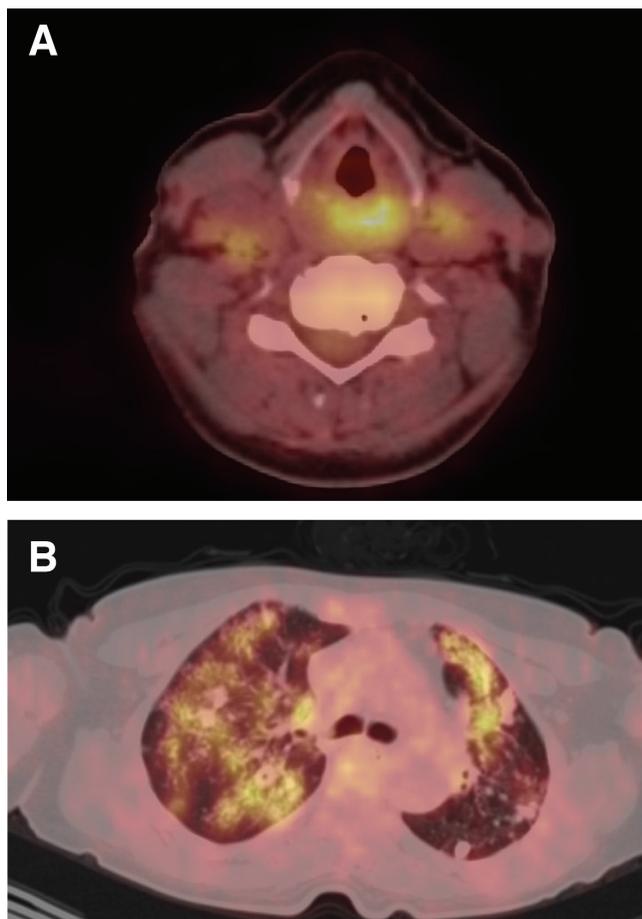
PET/CT fusion images showed hypermetabolic foci in the left aryepiglottic fold and interarytenoid area maximum standard uptake values (SUV_{max}): 8.9 (A). On transaxial thorax fusion images, there were multiple hypometabolic nodules (SUV_{max} : 1.5) and hypermetabolic infiltrations (SUV_{max} : 6) on both lungs, indicating tuberculosis (B)
